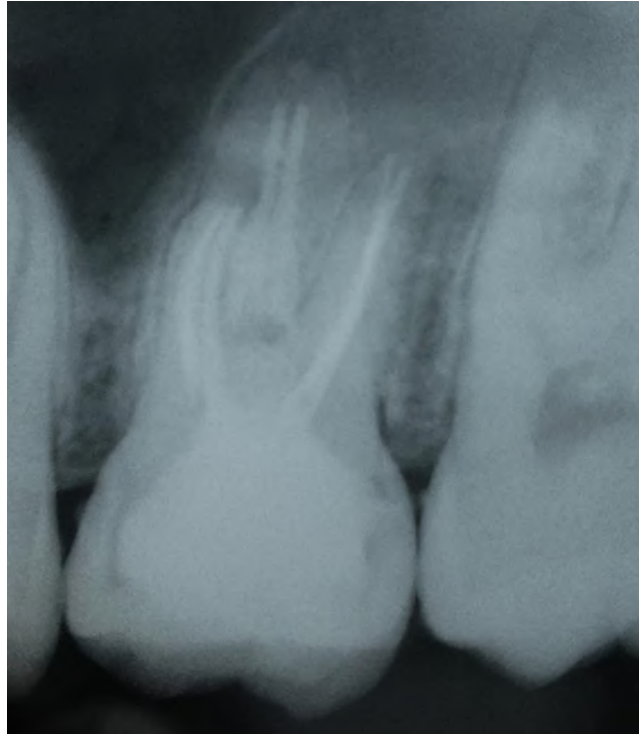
final radiography.
